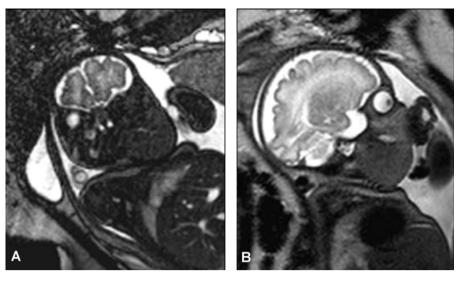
T2-weighted foetal MRI showing the large left cervical tumor: coronal (A) and saggital (B) views.
